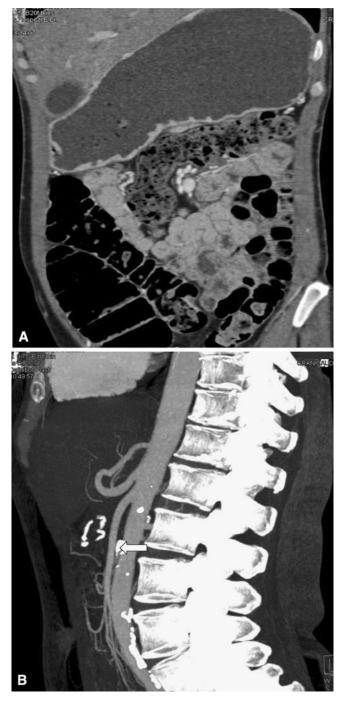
A 45-year-old female with a roughly 18-month history of progressive abdominal pain, bloating, and anorexia, with fear of eating. Coronal CT image (\mathbf{A}) demonstrates a markedly dilated stomach, while a sagittal MIP image (\mathbf{B}) demonstrates a narrowed aortomesenteric angle and distance, with compression of the duodenum (*arrow*). She subsequently underwent a laparoscopic side-to-side gastrojejunostomy, with resolution of her symptoms.
